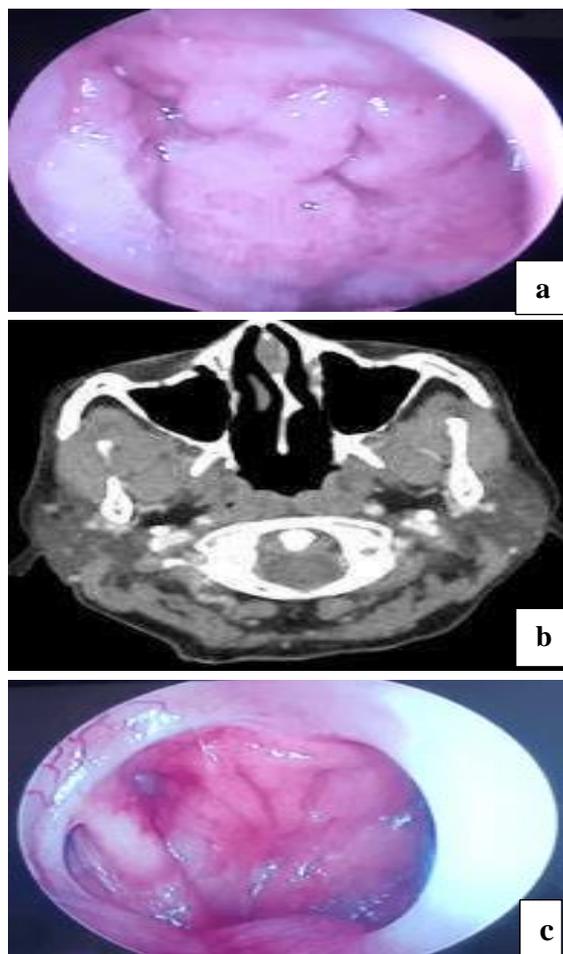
Serial follow-up images demonstrating no residual or recurrent lesion in the nasopharynx. (a) Nasal endoscopy at 3 months post-treatment. (b) Axial cut of contrast-enhanced CT scan at 3 months. (c) Nasal endoscopy at 1-year follow-up confirming sustained remission
